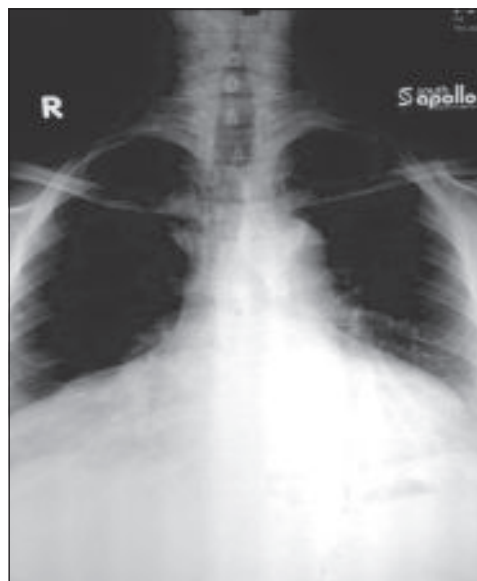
Chest X-ray postero-anterior view showing the lesion occupying the right lower zone.
